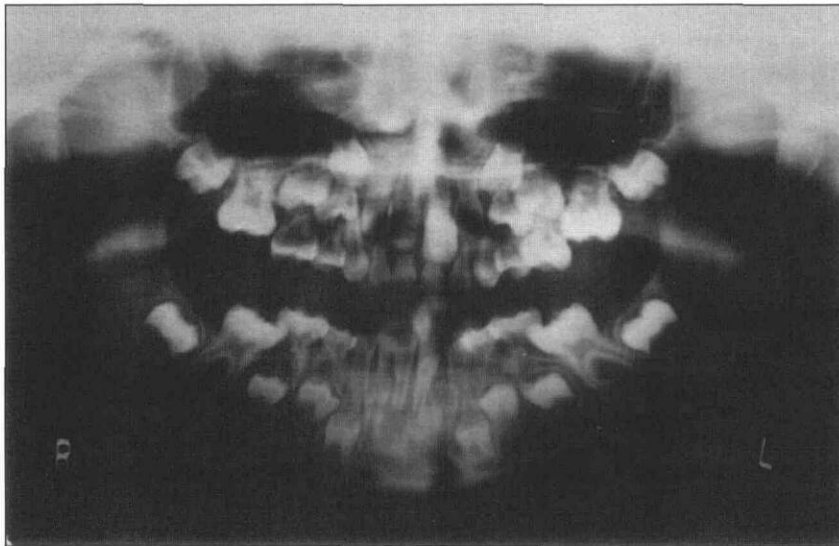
Panoramic radiograph of patient at age 7 years showing the severe ectopic eruption of both mandibular permanent molars.
